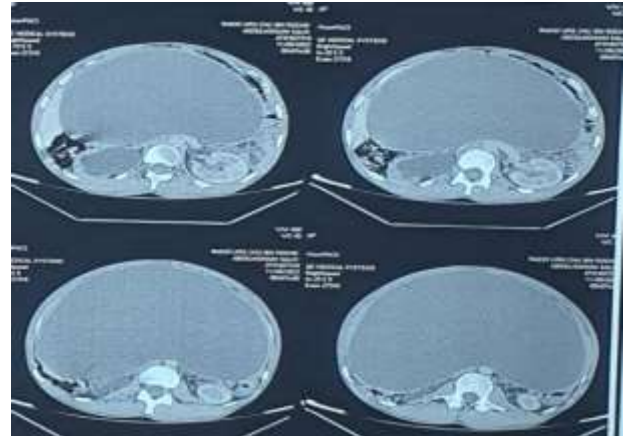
CT appearance of the cyst on a transverse
